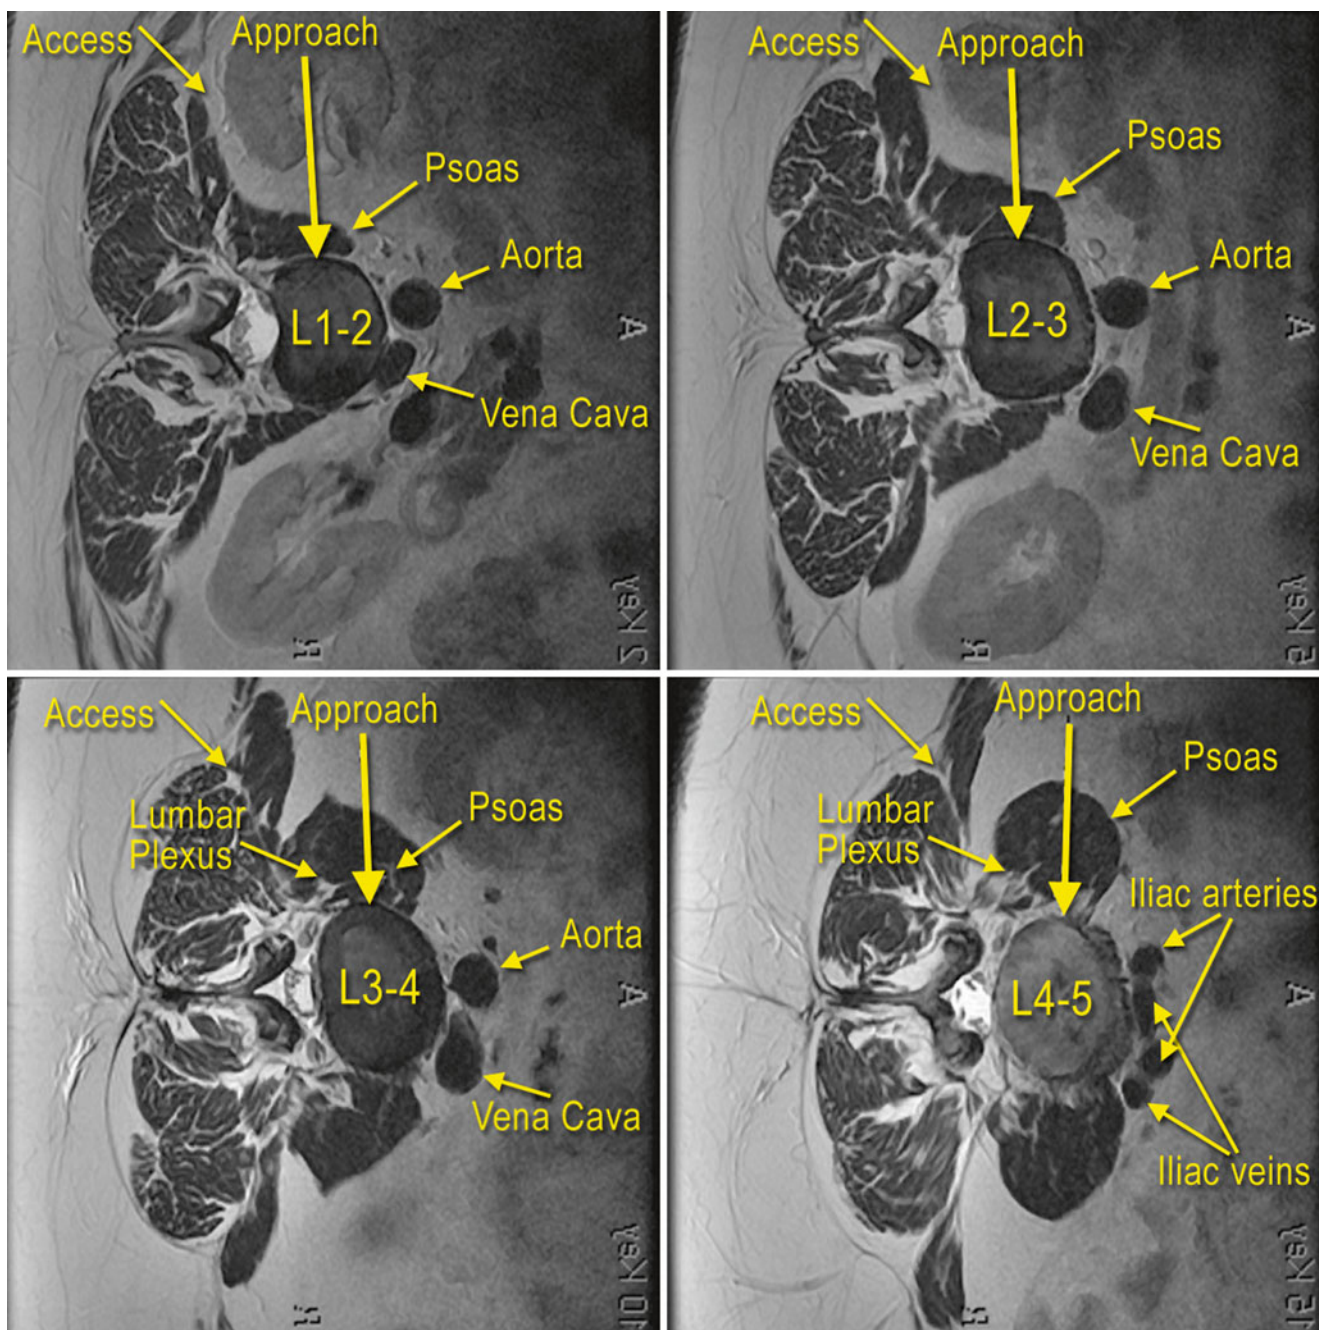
Axial magnetic resonance imaging showing the anatomy relevant to the lateral approach thoracolumbar interbody fusion at the disc levels for L1–2 (*upper left*), L2–3 (*upper right*), L3–4 (*lower left*), and L4–5 (*lower right*)
